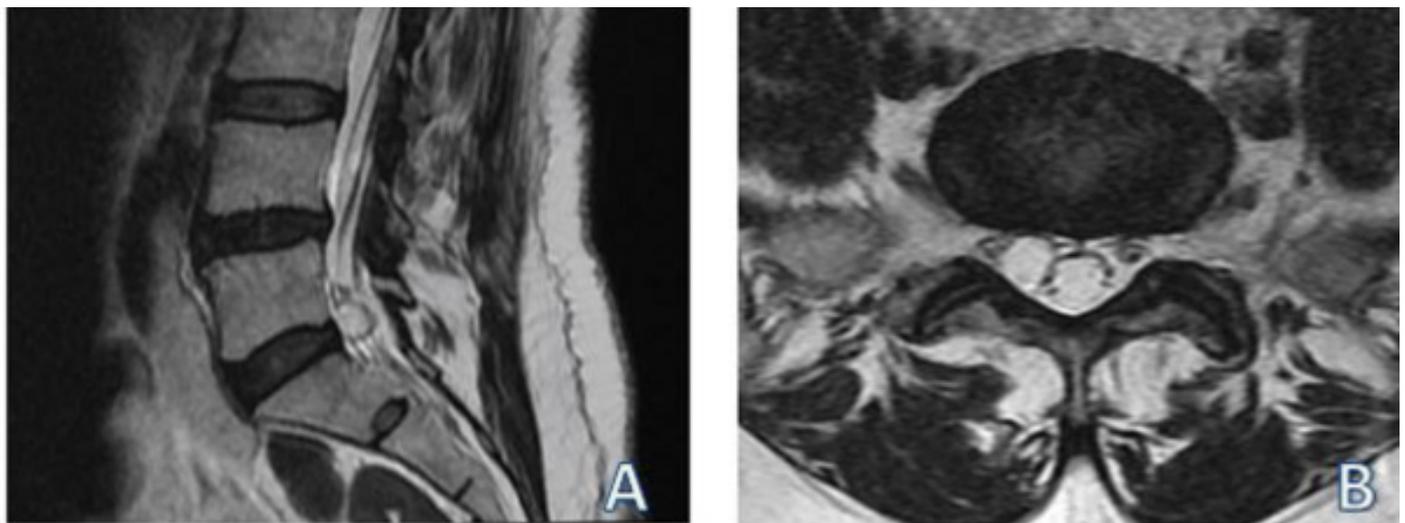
Sagittal (A) and axial (B) T2-weighted images show synovial cyst at the right foraminal recess
